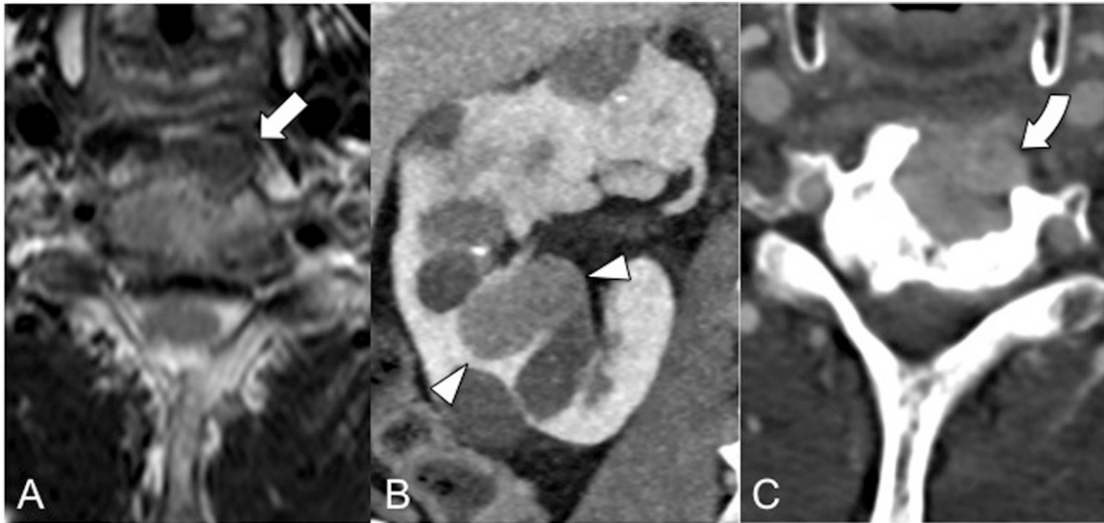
(A) 1.5-T axial plane T2-weighted MRI demonstrating a metastatic soft tissue mass in the left anterolateral cortex of C6 (straight arrow). (B) Contrast-enhanced CT scan in coronal plane of the right kidney shows multiple cortical cysts and a solid tumor mass (arrowheads). (C) Contrast-enhanced CT scan in axial plane reveals marked growth of the C6 metastatic mass, which has caused a large lytic cortical lesion (curved arrow).
